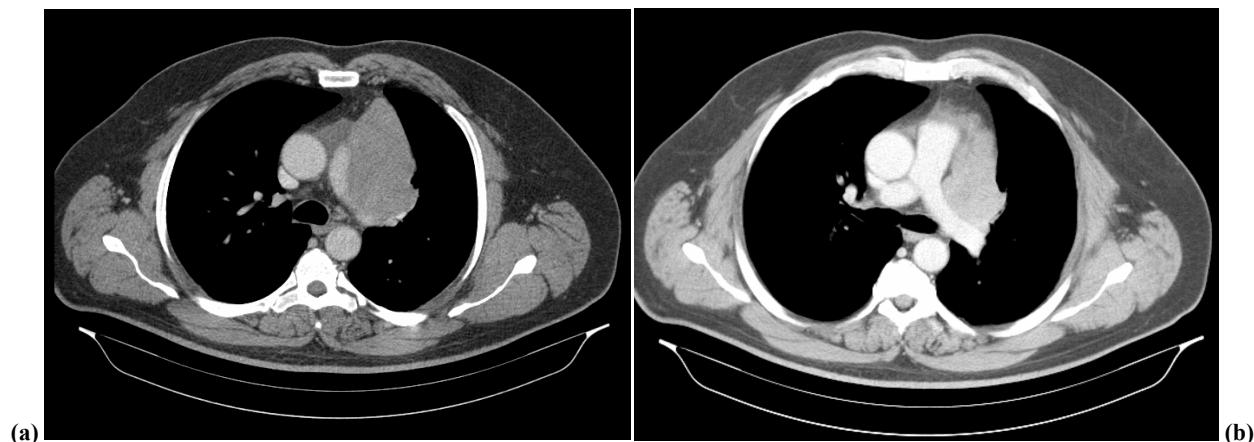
(a, b) CT thoracic scan – with contrast i.v. iodinated medium – prevascular heterogeneous mass in the prevascular space, that lies near left pulmonary artery, associated with other mediastinal adenopathies; due to the presence of pulmonary fibrosis and atelectasis it was considered to be pulmonary tumor T2, N2, Mx; there was no sign of pleural and pericardial invasion in time of diagnosis.
